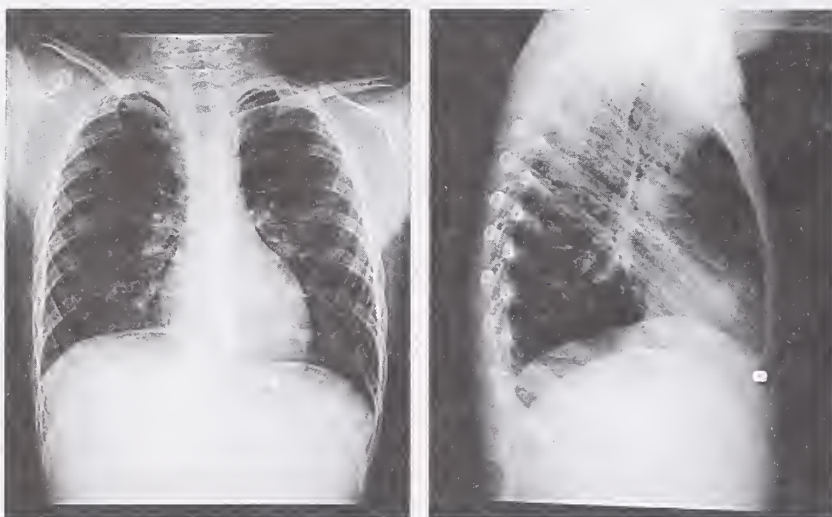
Posterior-anterior (a) and lateral (b) chest radiographs demonstrating pellet location.
